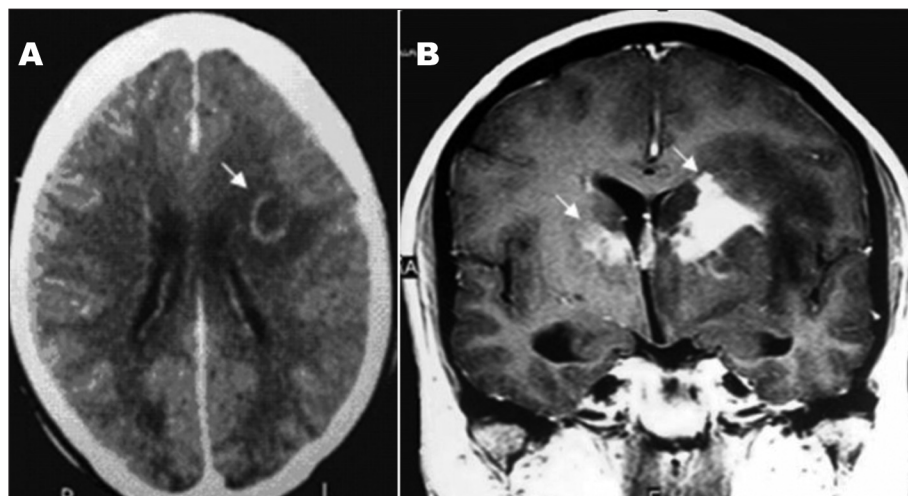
(A) CT-scan: expansive mass on the left cerebral hemisphere (arrow). (B) T1-weighted MRI: bilateral homogeneously-enhanced lesions (arrows).
